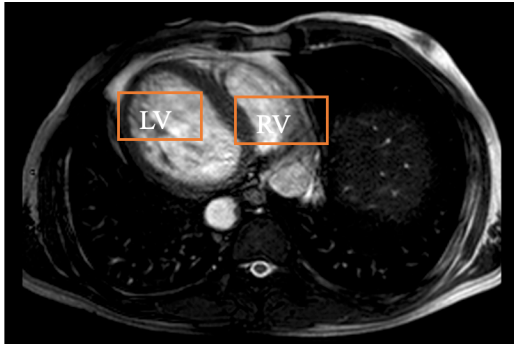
Magnetic resonance image showing dextrocardia.
